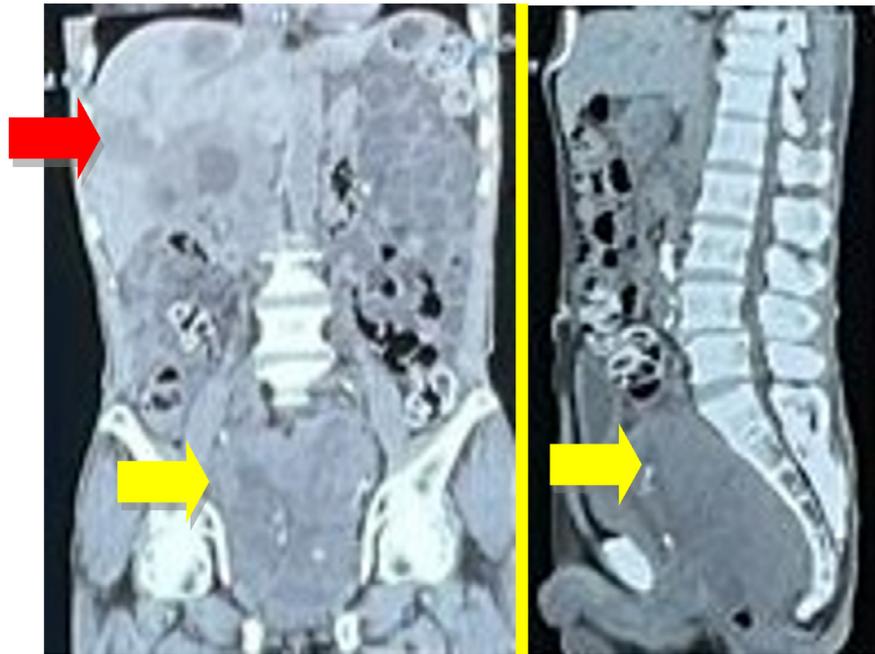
Abdominal non-contrast computerized tomography (CT) scan. A large lobulated mass in the pelvic cavity extended to posterior (yellow arrow) and multiple lesions in the liver (red arrow).
